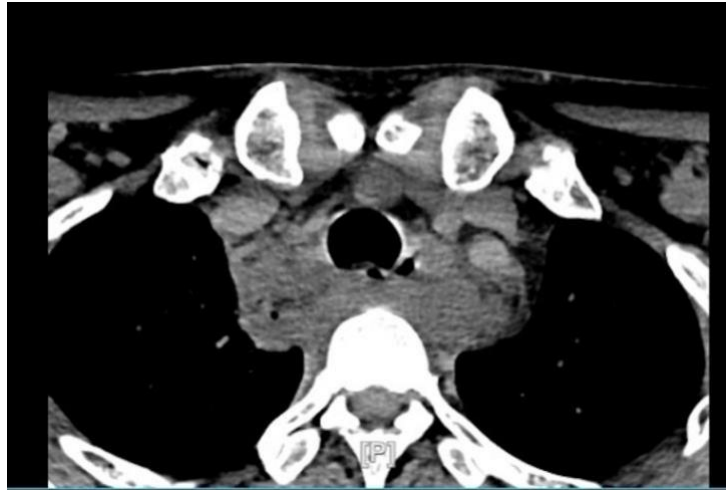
CT scan of the Mediastinum showed air fluid
